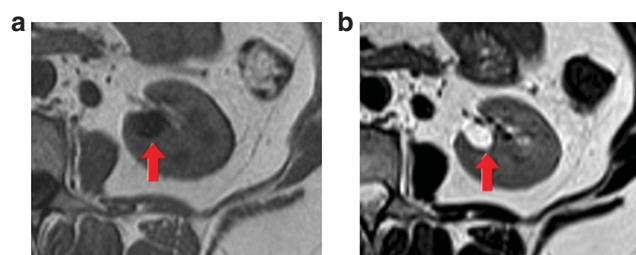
Conventional anatomic magnetic resonance imaging (MRI) of kidney. The cyst, (a) with long T_1 , is dark on a T_1 -weighted image, and (b) with long T_2 , bright on a T_2 -weighted image.
